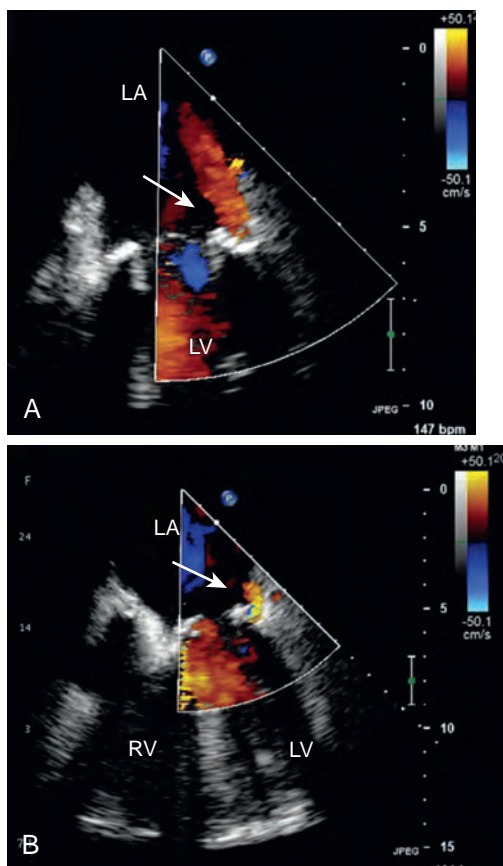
Paravalvular leak after mitral valve replacement. Bioprosthetic valve with a decreasing paravalvular leak (left to right). (A) Jet appears to be nonturbulent or of lower velocity. (B) Color Doppler jet area shows a significant reduction in the regurgitant after administration of protamine. LA, left atrium; LV, left ventricle; RV, right ventricle.
